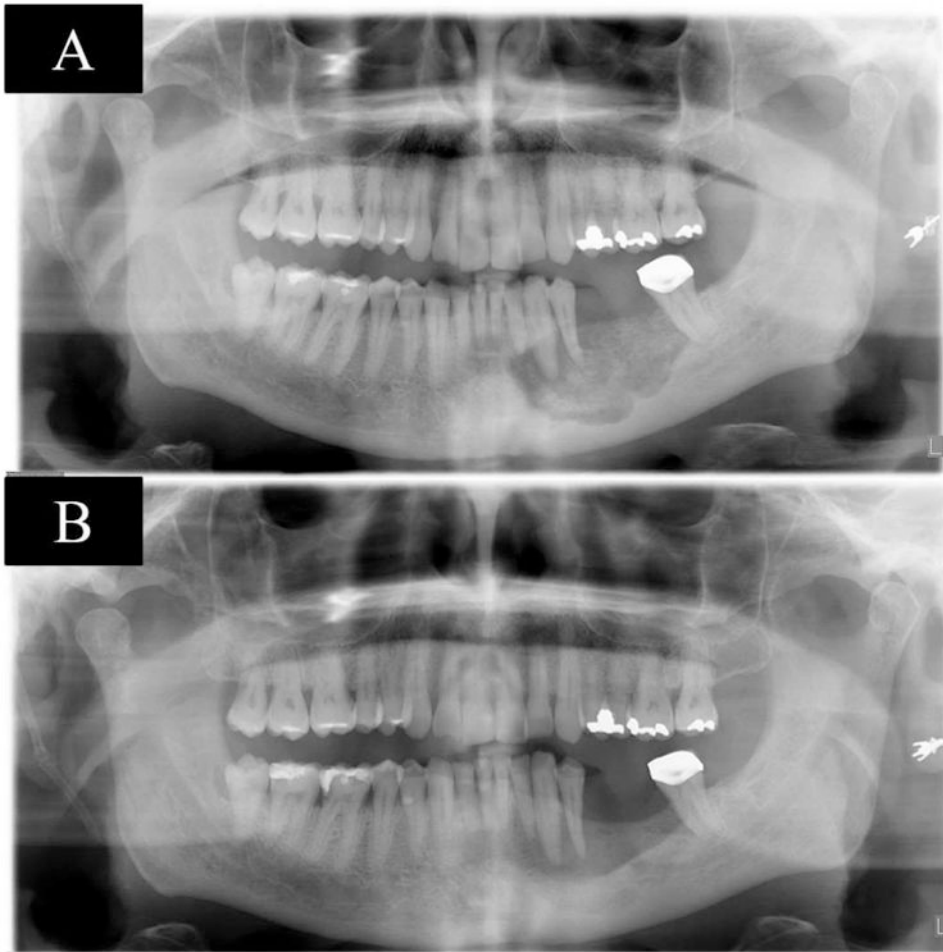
shows pre-therapy panoramic radiograph with a radiolucent defect (A), panoramic radiograph shows a radiographic bone fill after 34 months of therapy (B), case 1
